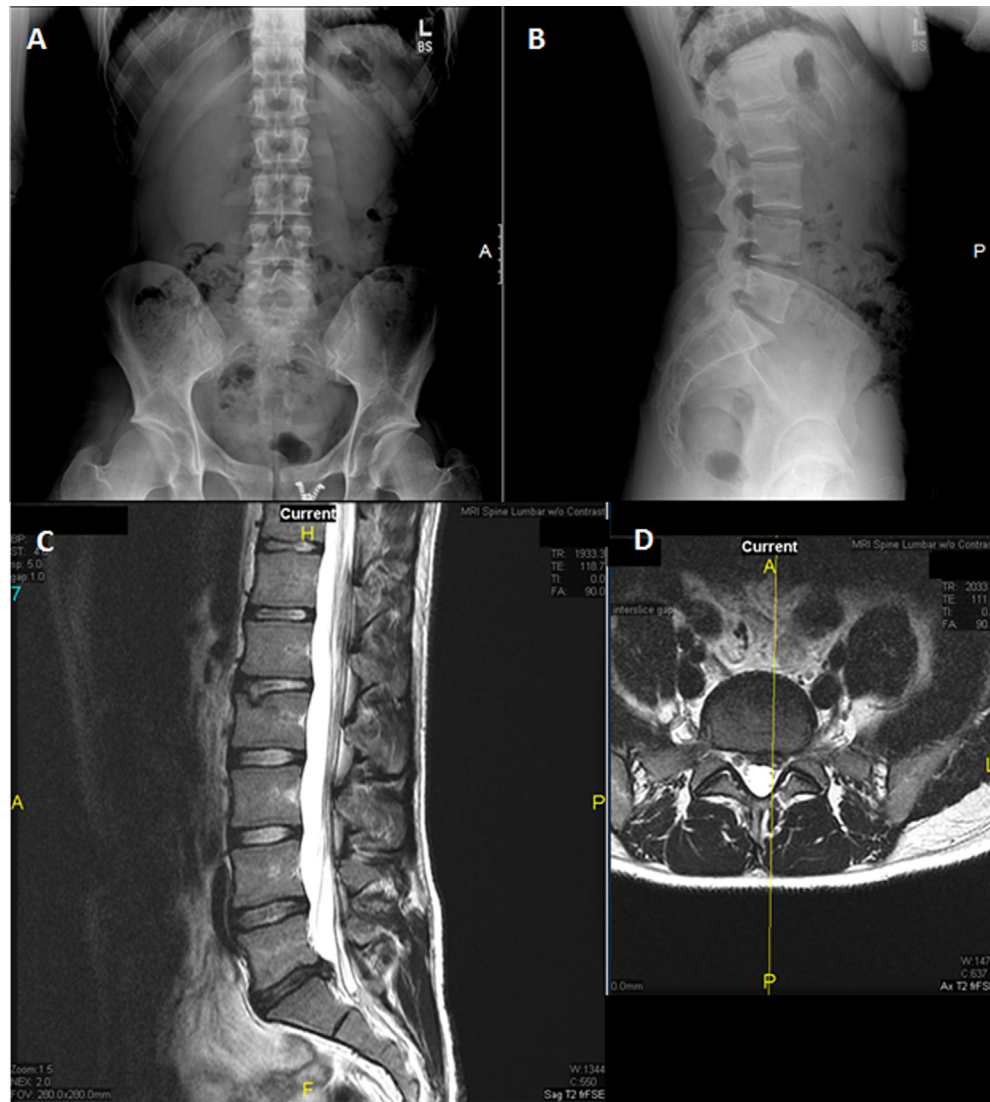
Preoperative AP (A) and lateral (B) plain radiographs in a 24-year-old male. Preoperative sagittal (C) and axial (D) T2-weighted fat-suppressed fast-spin-echo magnetic resonance images showing a prominent left L5–S1 disc herniation.
